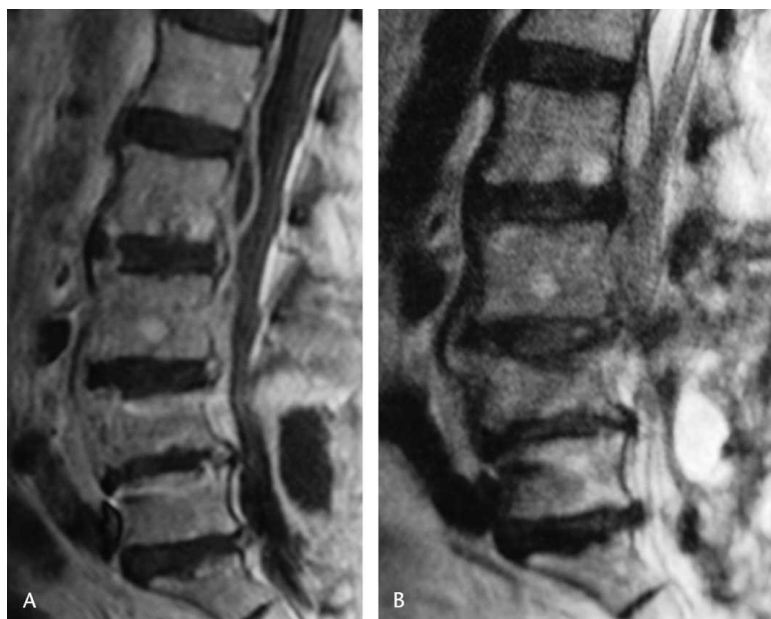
A 72-year-old woman with bilateral leg pain secondary to spinal stenosis, had an L₄ and L₅ decompression laminectomy, bilateral L₅ foraminotomy, transpedicle L₄, L₅, S₁ instrumentation, and bilateral facet fusion. Seventeen days later, she reported having severe back pain. The MRI scans were indicative of spinal infection. (A) The T₁-weighted image shows a lesion with low signal intensity posterior to the L₄ and L₅ laminectomy site, in the paraspinal muscles. (B) The same lesion shows moderately increased intensity on the T₂-weighted image.
